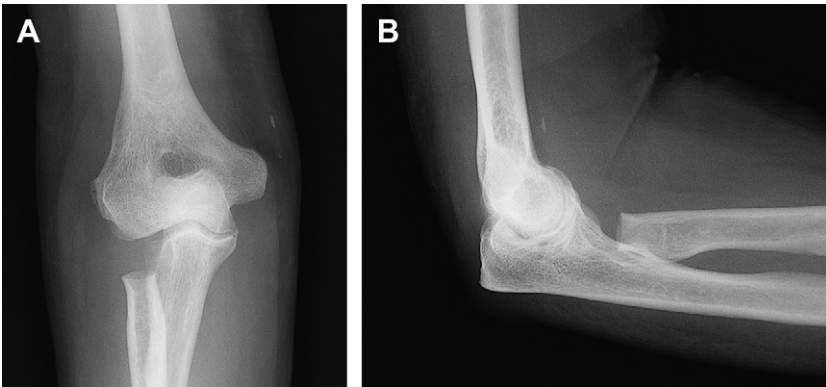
(A) Anteroposterior and (B) lateral radiographs after radial head excision.
